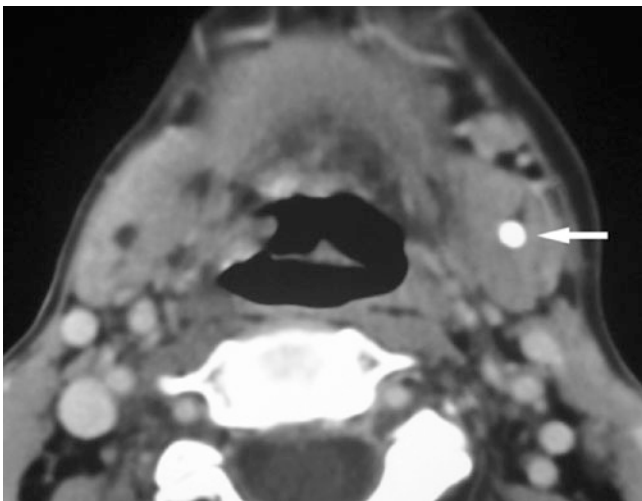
Submandibular gland stone; 79-year-old female with left submandibular mass for about 2 months. Axial post-contrast CT image shows stone in the hilum of submandibular gland (*arrow*)
